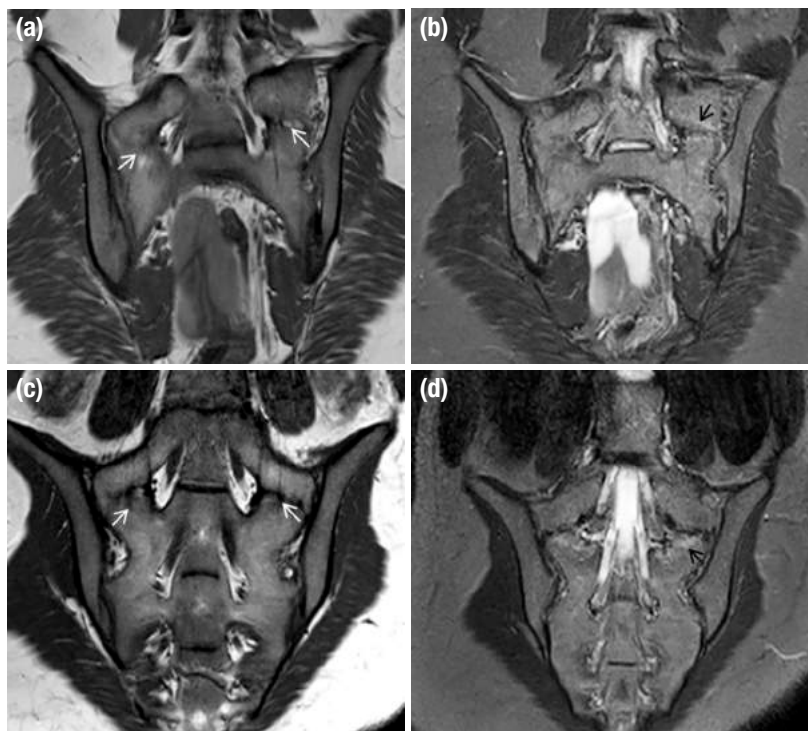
a–d. Magnetic resonance imaging of SIJ demonstrates Castellvi type IV (a) and type II B (c) sacralizations (white arrows) on paracoronal T1-weighted images. Contrast-enhanced fat-saturated T1-weighted images (b, d) demonstrate bone marrow edema at both sides of sacralization (black arrows).
